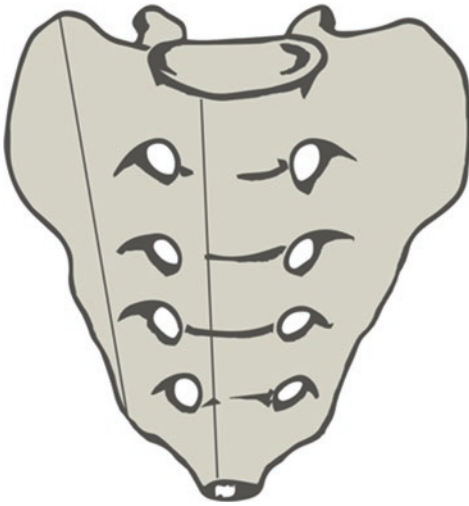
(a–g) Precipitated patient in attempted suicide. Complex fracture (CM); condition of high instability. (a–c) CT axial view; (d) CT MPR coronal view; (e) CT MPR sagittal view shows fracture and dislocation of the sacrum, fracture of the right sacral wing, and avulsion
